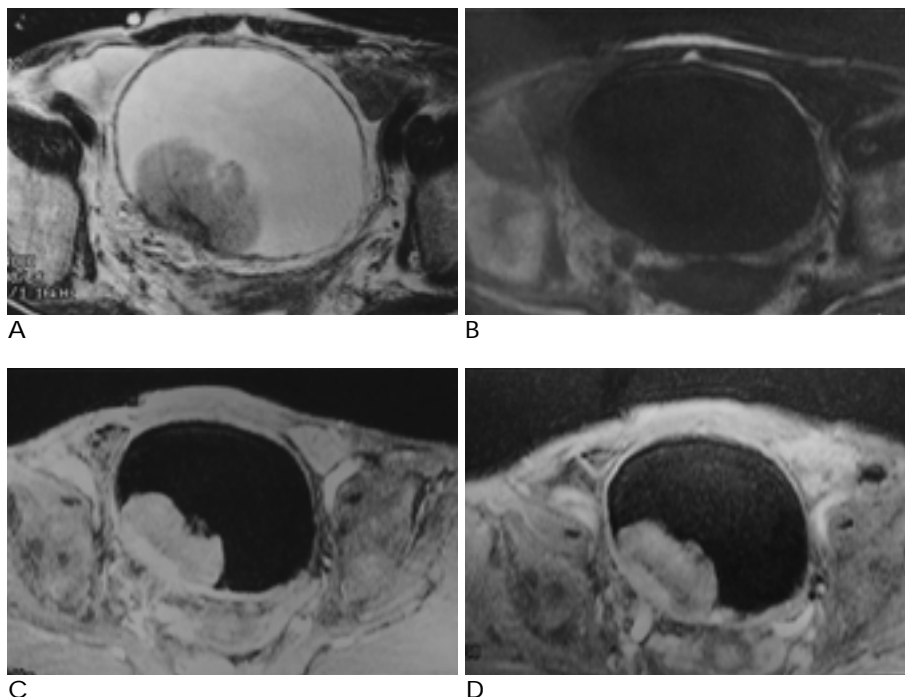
Transitional cell carcinoma of the bladder, stage pTIIlb. Axial T2-weighted image (A), preenhanced dynamic image (B), capillary phase of Gd-enhanced dynamic image (C), venous phase of Gd-enhanced dynamic image (D) show a protruding mass in the right posterior wall. Invasion to the perivesical fat is not clear on T2-weighted image (A), but can be demonstrated on dynamic Gd-enhanced image where the perivesical fat is well enhanced.
